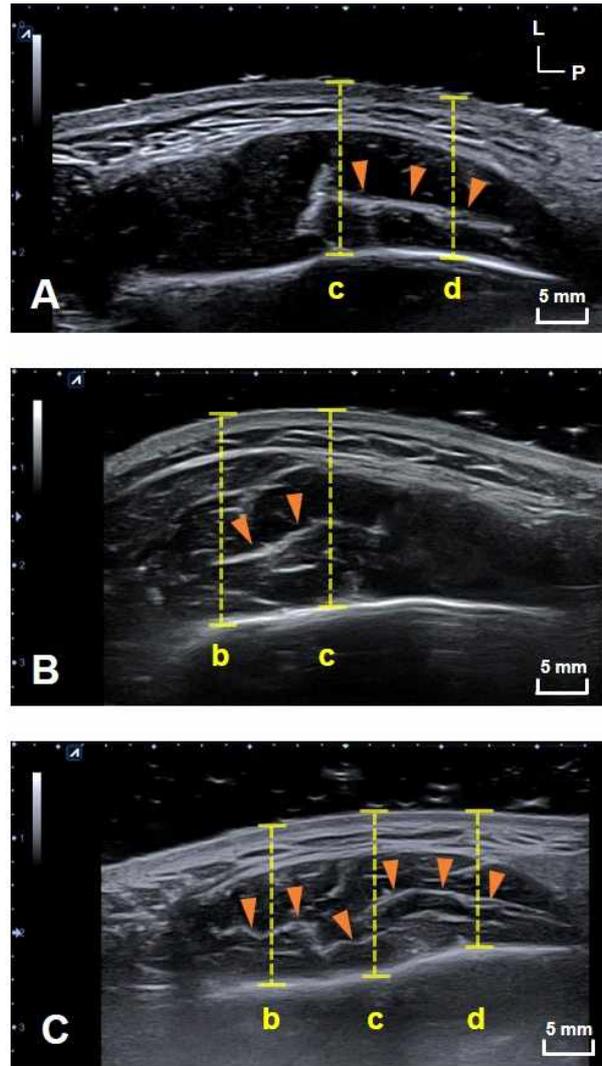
Transverse ultrasonography image depicting the masseteric area including deep inferior tendon within the muscle. The depth from the skin to mandible (yellow dashed line) and from mandible to DIT (blue dashed line) at reference lines B, C, and D were measured on the transverse ultrasonography. Longitudinal reference lines is as follow: half-way point between anterior border of the masseter m. and c (b); half-way point between anterior and posterior border of the masseter m. (c); half-way point between c and posterior border of the masster m. (d).
